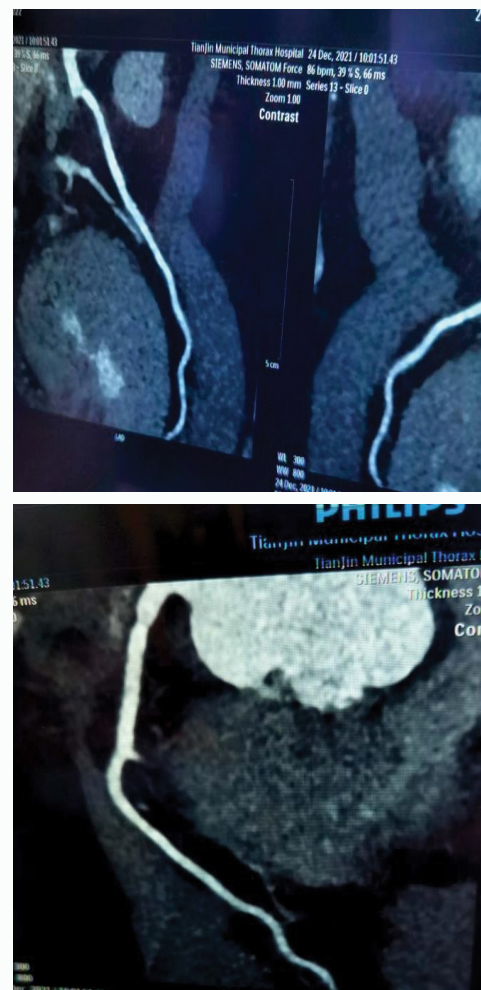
Coronary CTA indicated no significant stenosis of left coronary artery LAD CLX or RCA.
